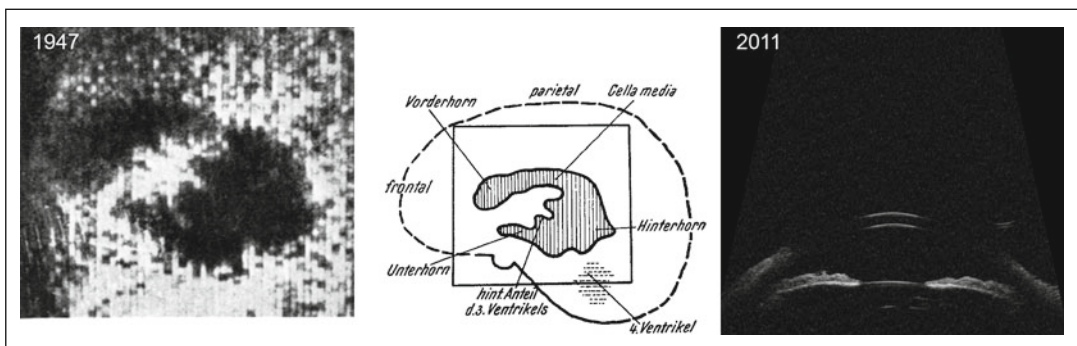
Left*: one of the first ultrasound images was taken of the human skull by Karl Dussik (1947). When passing through the ventricle, the beam is less attenuated. *Middle*:
